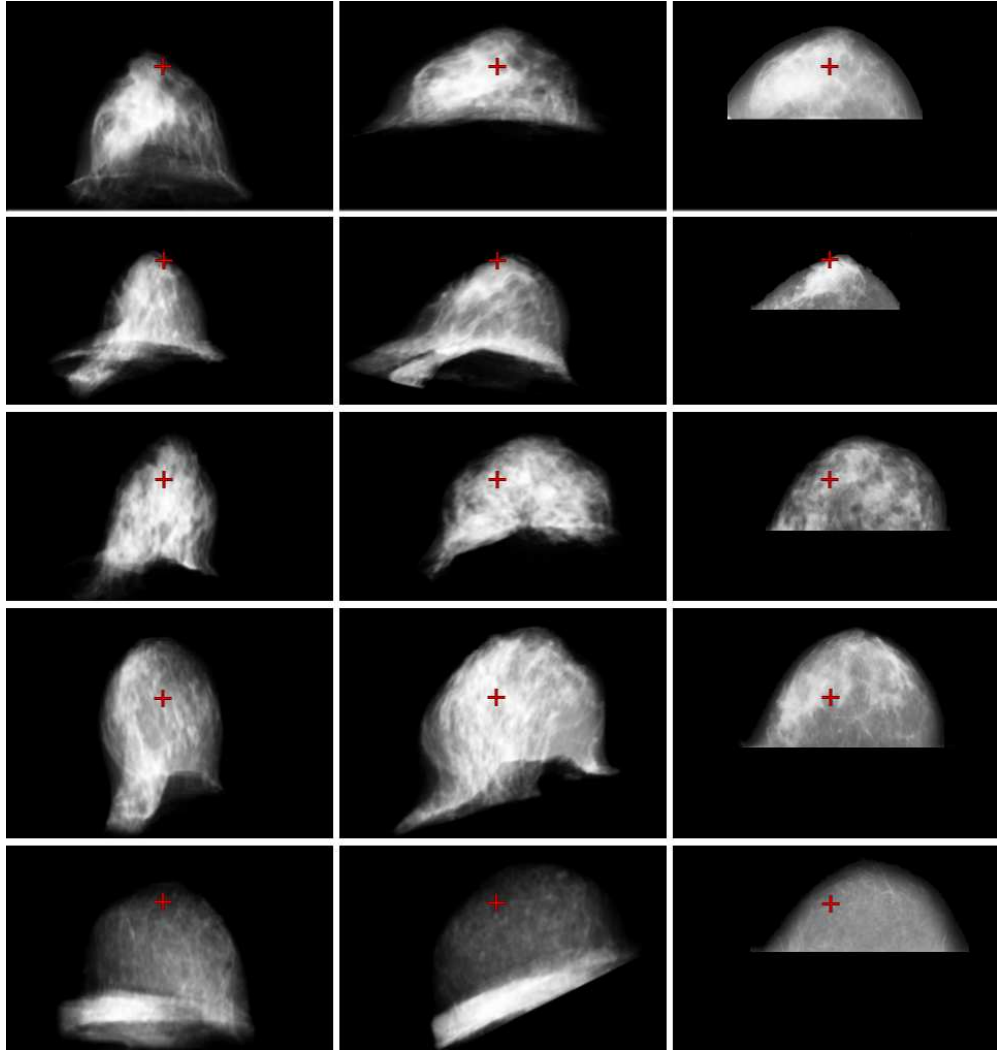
Registration results on real data (5 cases, one per row). From left to right: projection of the source volume before registration, after registration and real X-ray mammogram. The red cross indicates the position of a corresponding coordinate in each image.
